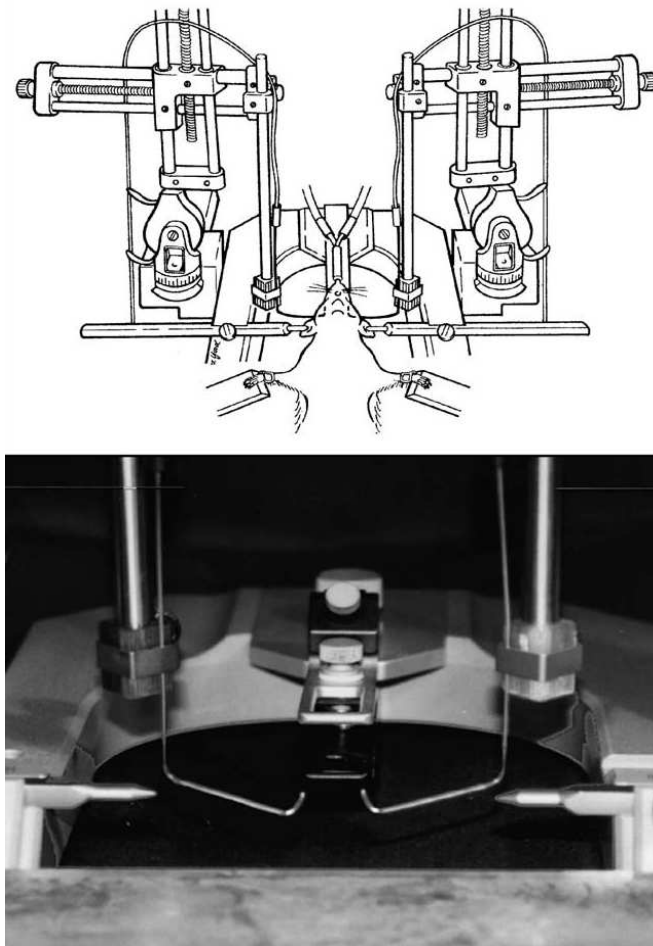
Experimental setup for cerebral blood flow measurements using laser Doppler Flowmetry (Image from Hungerhuber (2006))
